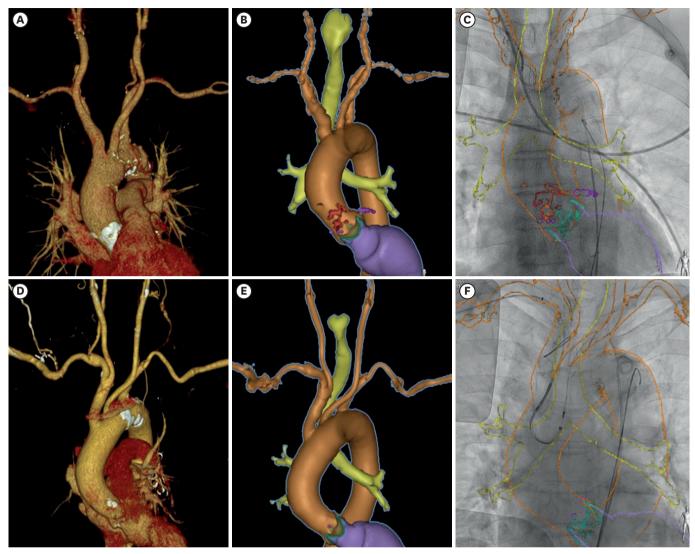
Images of CT merged with cerebral protection system insertion.
